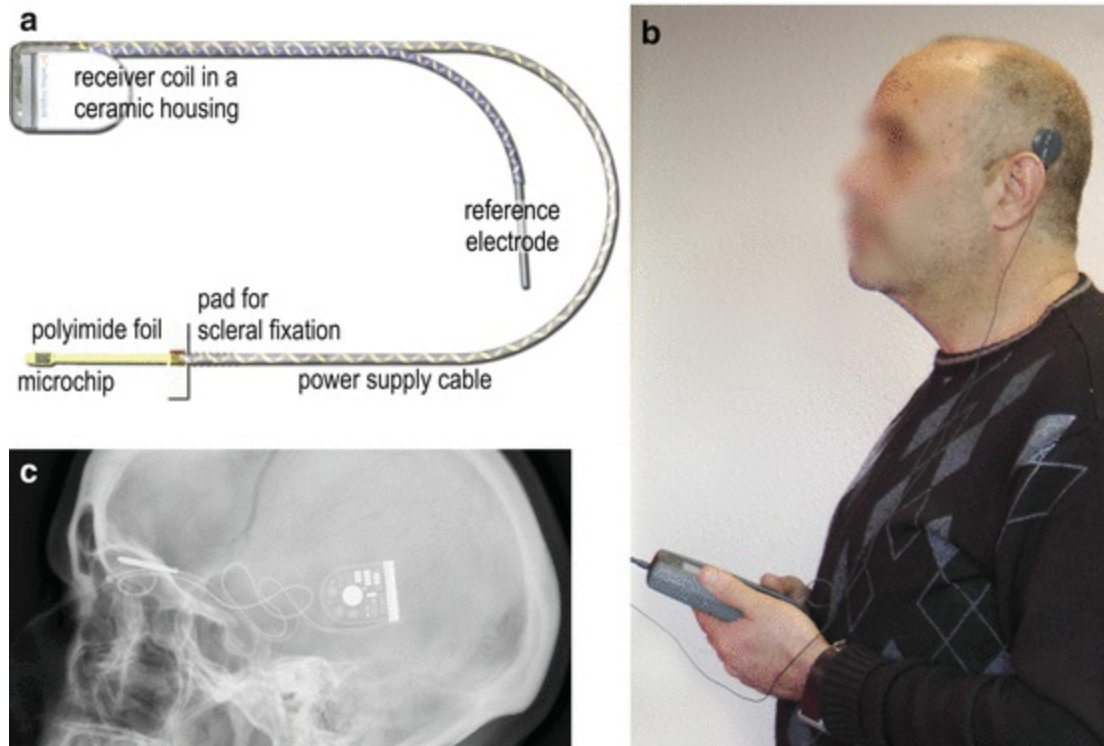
(a) The Retina Implant Alpha IMS consists of the microchip (micro-photodiode array) on the tip of a polyimide foil (both placed subretinally), a power supply cable connecting the microchip with the receiver coil in a ceramic housing in the retroauricular region and the reference electrode placed subdermally near the temporal muscle. (b) Power and signals are sent wirelessly through the skin via a transmitter antenna coil (black) which is kept in place behind the ear with a subdermal magnet. The patient can switch on or off the device on the hand held unit, as well as adjust contrast sensitivity and brightness manually via two knobs. (c) As seen in the X-ray image, an implanted cable leads from the subdermal receiver coil behind the ear to the intraorbital space, where it connects to a subretinal foil. The electronic circuits in the chip are powered and controlled by electronics in the subdermal receiver coil behind the ear
